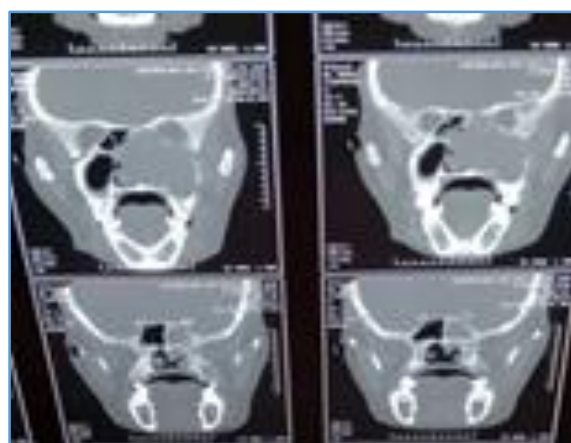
CT Scan: An ill-defined soft tissue density lesion in the right maxillary sinus
